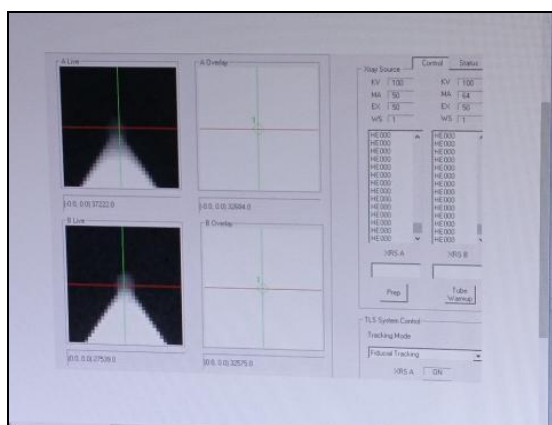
For X-ray tube B
